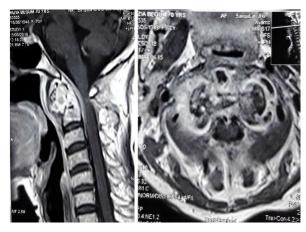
MRI of cervical spine sagittal section-post contrast sequence showing heterogeneous contrast enhancement with sub ligamentous spread of the pus causing narrowing of oropharyngeal lumen (A) , T2WI axial section showing both pre and paravertebral soft tissue collection (B).
